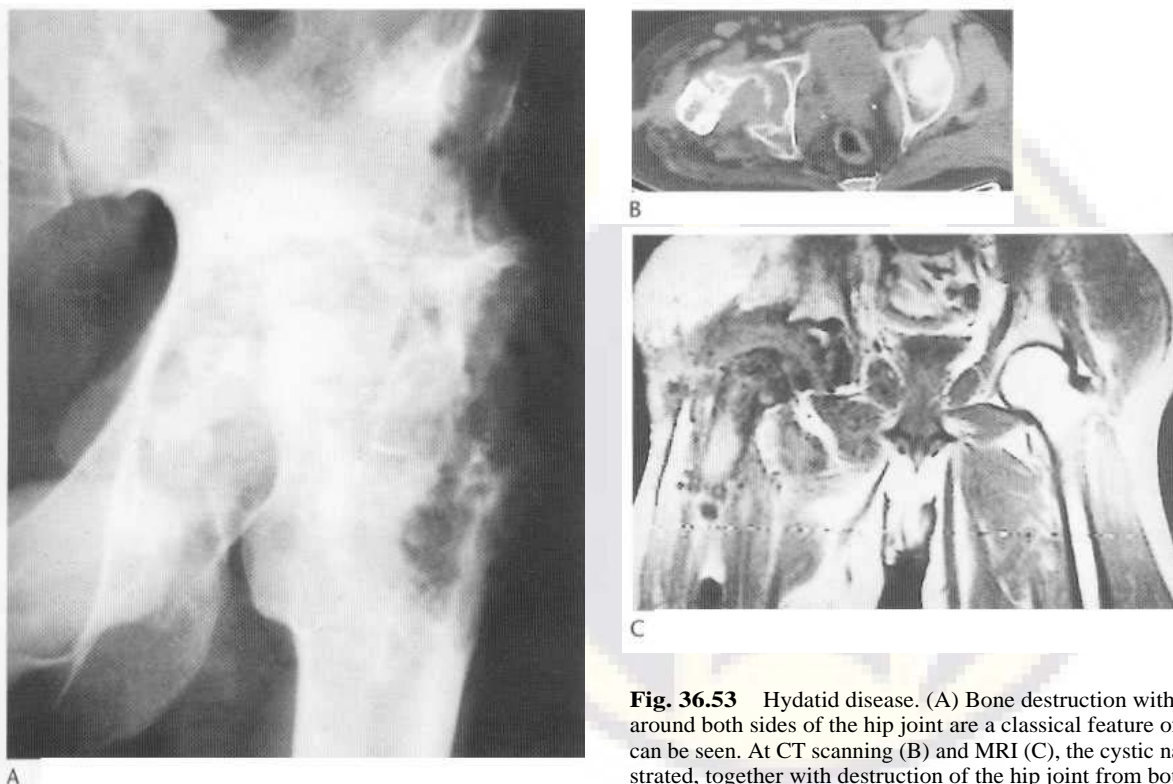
Hydatid disease. (A) Bone destruction with the formation of large cysts around both sides of the hip joint are a classical feature of osseous hydatid. Sequestra can be seen. At CT scanning (B) and MRI (C), the cystic nature of the lesions is demonstrated, together with destruction of the hip joint from both sides.
